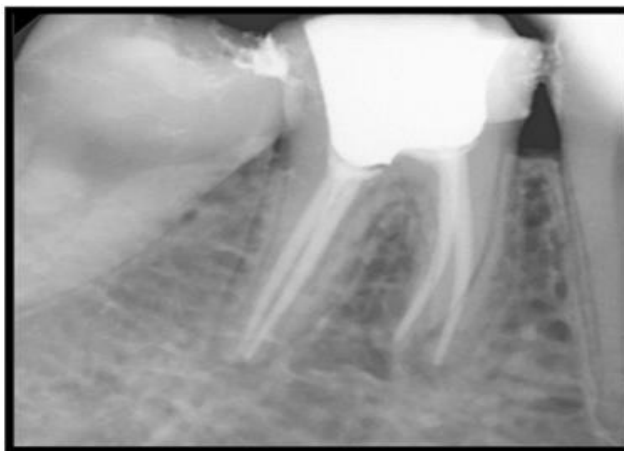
Radiograph showing post endodontic restoration of #46
